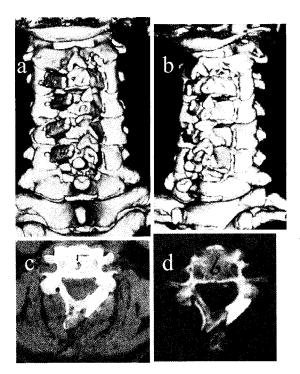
Representative postoperative computer tomography (CT) scans obtained 3 months after surgery in a 65-year-old man. a,b Three dimensional bone CT showing fine fixation of hydroxyapatite (HA) implants from C3 to C6. c,d CT scan at C5 and C6, respectively, demonstrating fusion of HA spacers with the lamina and lateral mass
